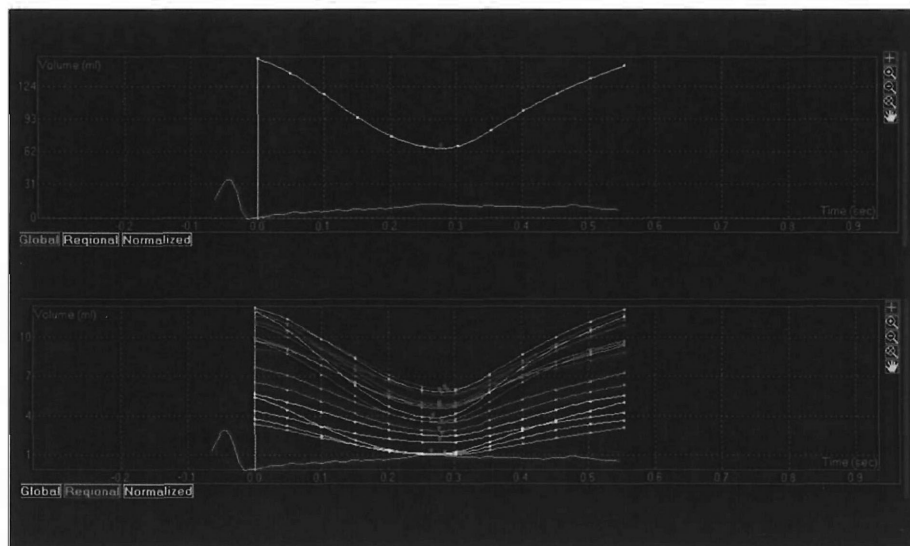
Assessment of LV volumes and ejection fraction by real time three-dimensional echocardiographic images. Endocardial and epicardial boundaries are traced manually and used to calculate LV end-diastolic volume (a) and end-systolic volume (b). The report of global systolic function is shown in the upper panel (c). LV volume-time curves (d) described LV global and regional performance beyond ejection fraction.
